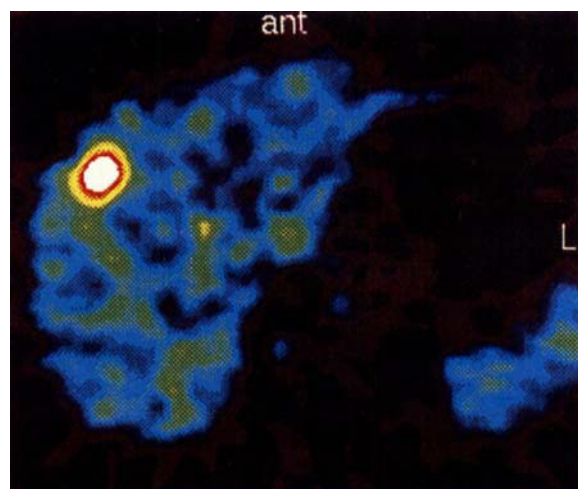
Patient with an ileal carcinoid (case No. 1) and a solitary liver metastases in the right liver lobe as indicated by ultrasonography. CT failed to detect the tumor. The patient demonstrated normal levels of urinary 5-HIAA but slightly increased chromogranin levels. PET shows an increased and well-defined uptake of ^{11}C -5-HTP in the liver metastasis.
